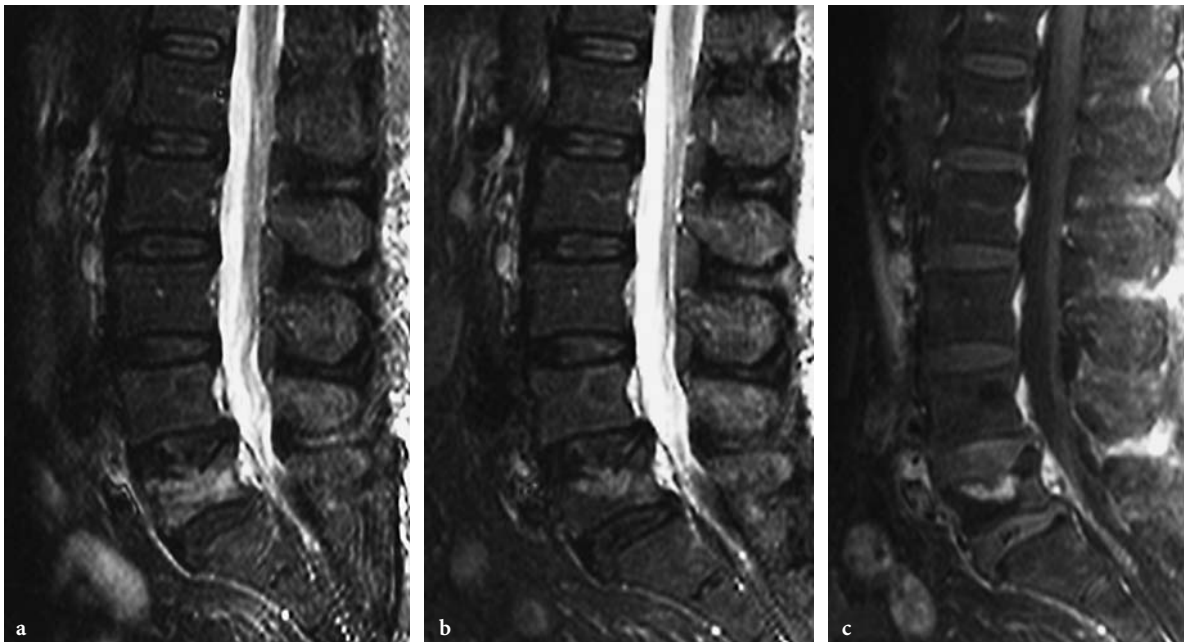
Pathologic fracture. a,b Sagittal T1- and FSE T2-weighted images demonstrate a pathologic fracture and complete replacement of the vertebral body by abnormal marrow signal intensit. c Post-gadolinium sagittal T1-weighted image with fat saturation technique shows multiple enhancing lesions consistent with metastatic involvement
